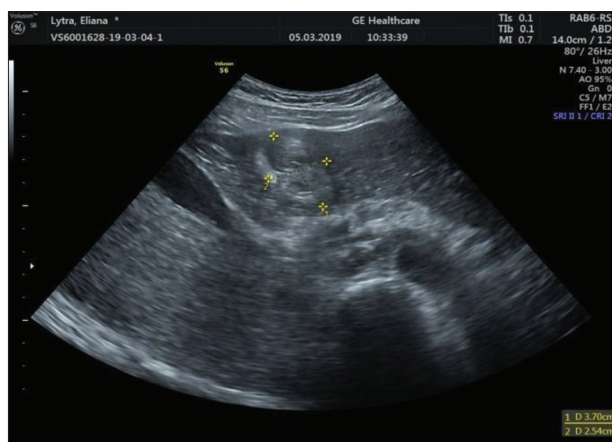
Ultrasonography finding: at first no significance was given to formation found in liver near hilus; differential diagnosis was liver hemangioma
